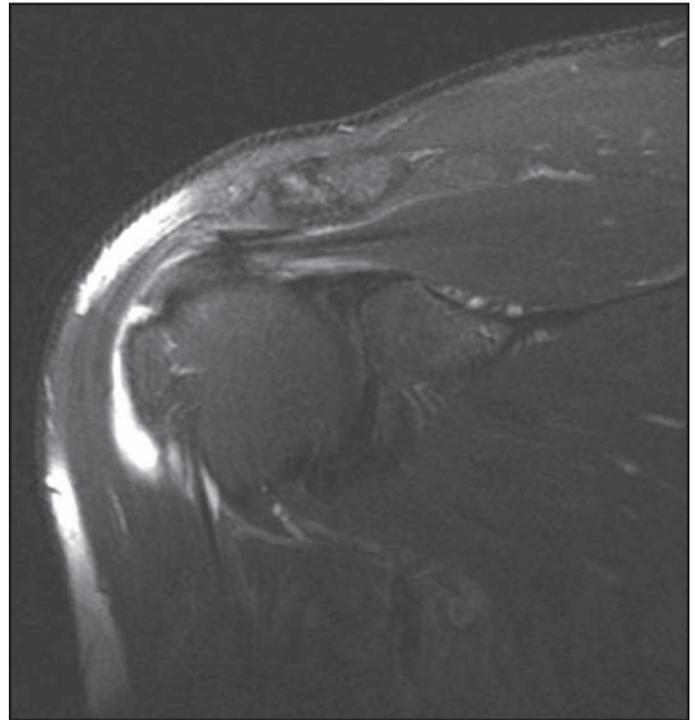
In this MRI, a partial tear of the rotator cuff is evident originating from the bursal side of the tendon. These types of lesions are less frequently encountered than articular sided lesions.
